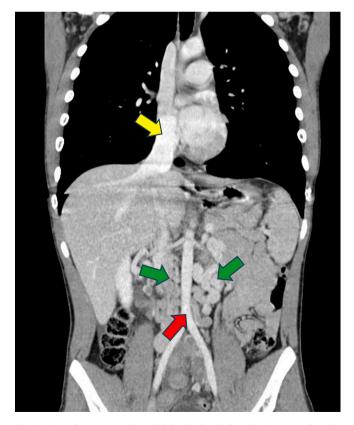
Coronal reconstruction of abdominal and thoracic CT scan of patient #2. Red arrow: abdominal aorta; green arrows: dilated and tortuous azygos veins with the absence of inferior vena cava; yellow arrow: dilated superior vena cava with drainage of hepatic flow.
